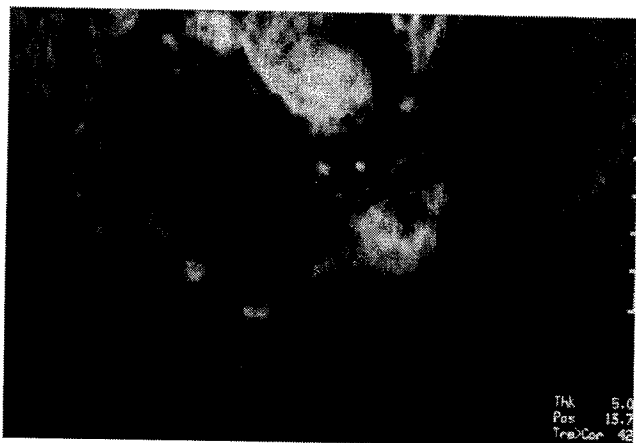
Short T1-weighted inversion recovery MRI of the pelvis in case 1, performed 3 weeks after onset of symptoms, demonstrates left sacral bone marrow edema with an interior area of bony sclerosis (arrows).
